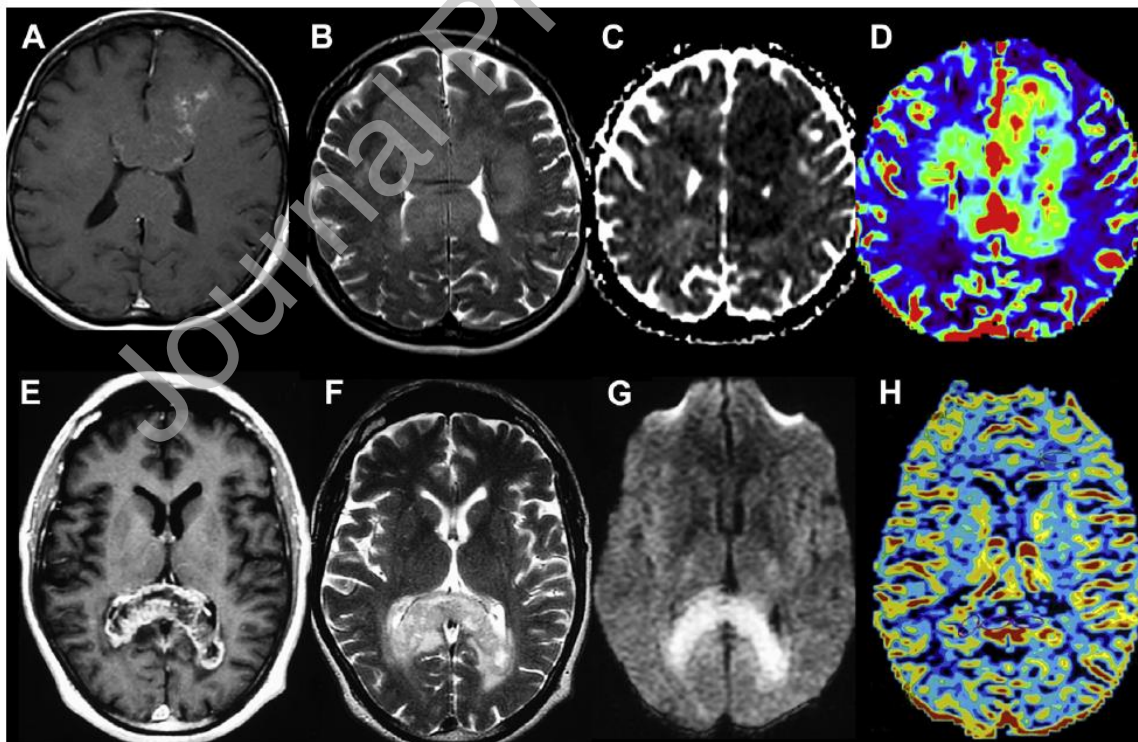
Glioblastoma (A–D). A not enhancing (A, postcontrast FSE T1-weighted image), infiltrating lesion (B, T2-weighted image), with restricted diffusion (C, ADC map) and high perfusion on DSC-MR imaging map (D, rCBV map) is seen in the frontal lobes, which involves the corpus callosum. Lymphoma (E–H). A contrast-enhancing (E, postcontrast FSE T1-weighted image) heterogeneous lesion, surrounded by edema (F, T2-weighted image), with restricted diffusion (G, high *b* value DWI image) is seen in the splenium of the corpus callosum. In contrast to GBM, the lesion does not demonstrate high perfusion on DSC-MR imaging sequence (H, rCBV map).
